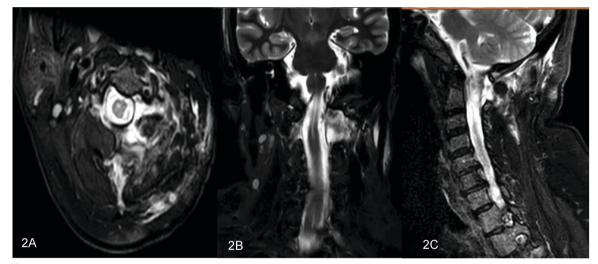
Postoperative axial (A), coronal (B), and sagittal (C) T2-weighted MRI image showing the near-total removal of the tumor.
